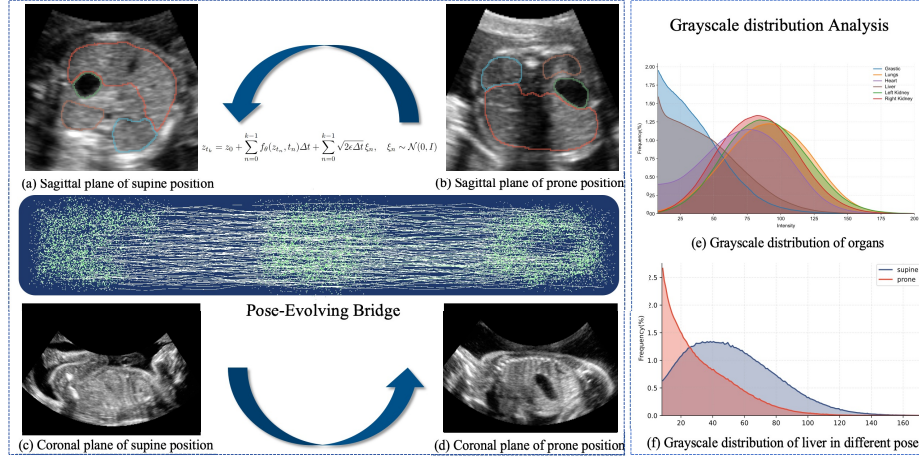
Overview of fetal thoracoabdominal volumetric ultrasound images and Pose-Evolving Bridge. (a,b) Abdominal organs in supine and prone positions; (c,d) Coronal views in supine and prone positions. (e) Grayscale distributions of all organs; (f) Liver grayscale distribution in supine vs. prone positions.
